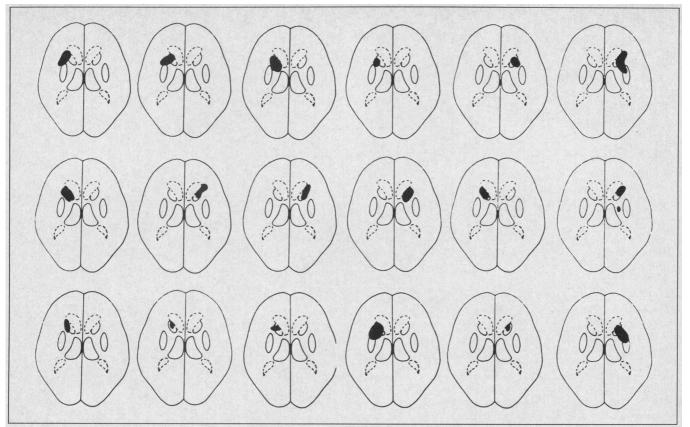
Montage of computed tomographic lesions at a plane through the superior thalamus charted on Stroke Data Bank grids. Patient 1 is charted at upper left and scans represent patients 1 through 18 from left to right. Patient 18 is at lower right extreme. The left hemisphere is on the viewer's left.
